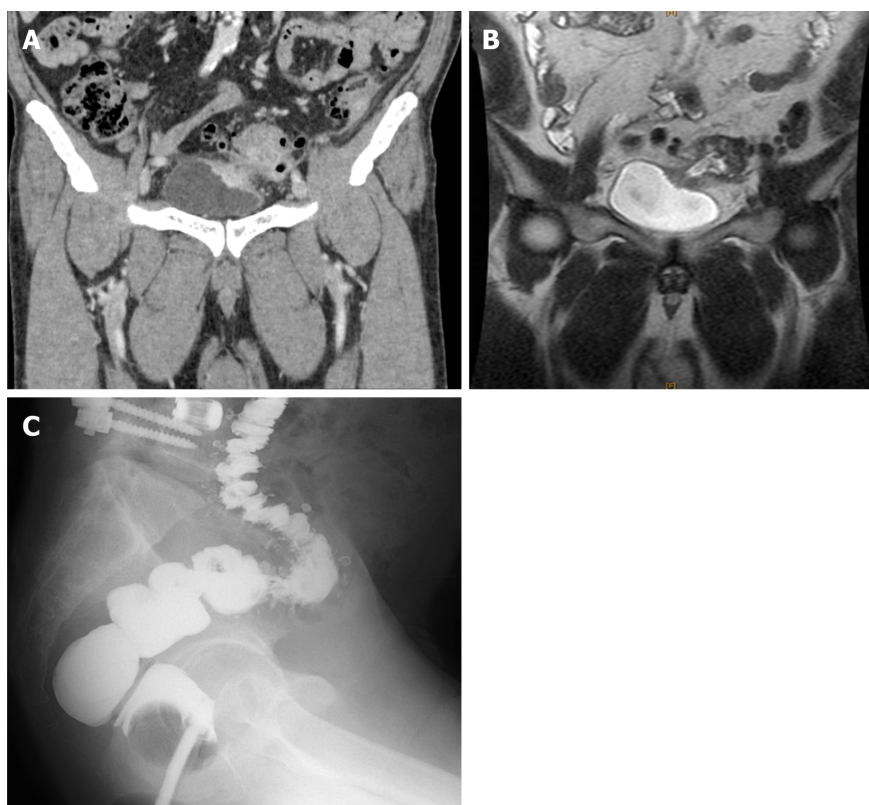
Preoperative computed tomography, magnetic resonance imaging, and gastrografin enema examination. A: The inflammatory changes around the intestinal tract continue to the left bladder wall, and the bladder wall is slightly thickened. Tumor cannot be seen; B: A penetrating portion continuous with the sigmoid colon is visible on the upper left side wall of the bladder; C: Only a diverticulum is found in the sigmoid colon.
